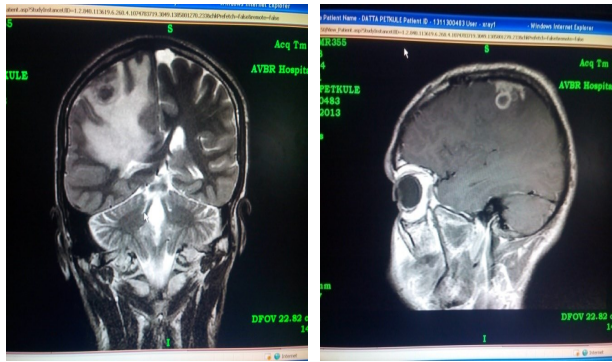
showing contrast enhancing MRI images of brain showing ring enhancing lesion in Right high parietal region with meningeal enhancement.
